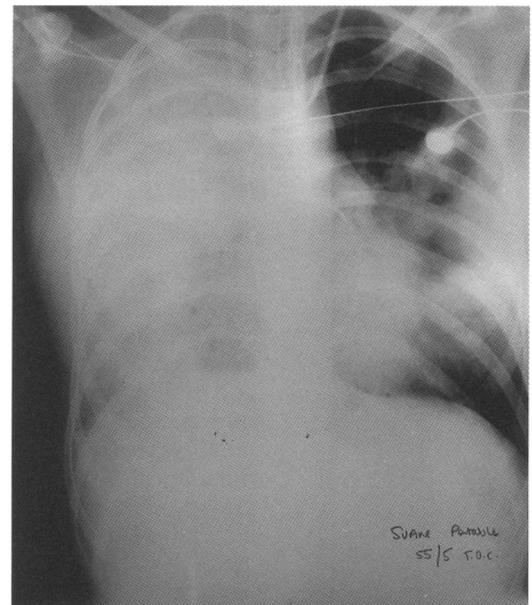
Anteroposterior chest radiograph at the time of admission (prior to instituting ECMO) showing bilateral pulmonary consolidation.
